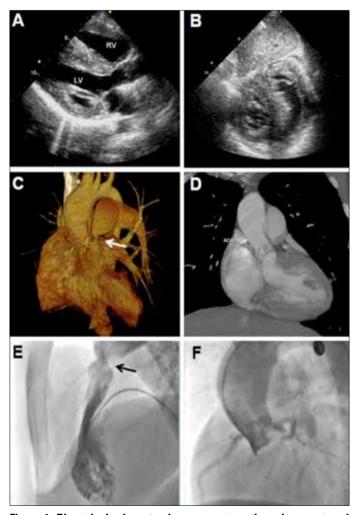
Biventricular hypertrophy seen on transthoracic parasternal long-axis (A) and substernal (B) echocardiographic views. Pulmonary infundibular stenosis seen on reconstruction image of 64-slice CT (white arrow) (C) and right ventriculography (black arrow) (E). Stenotic aortic root seen on 64-slice CT (D) and aortography (F)
